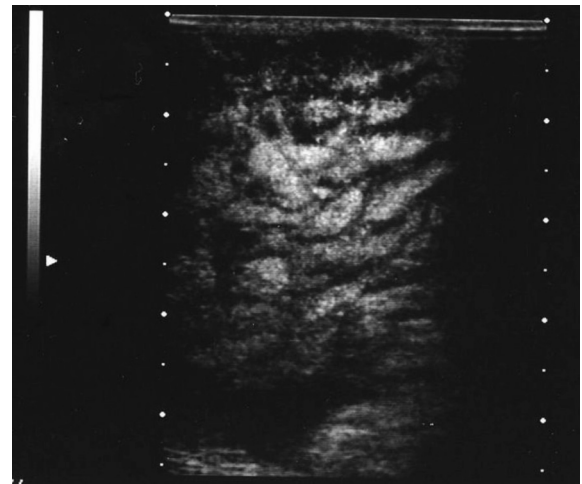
Ultrasonographic image of another patient
